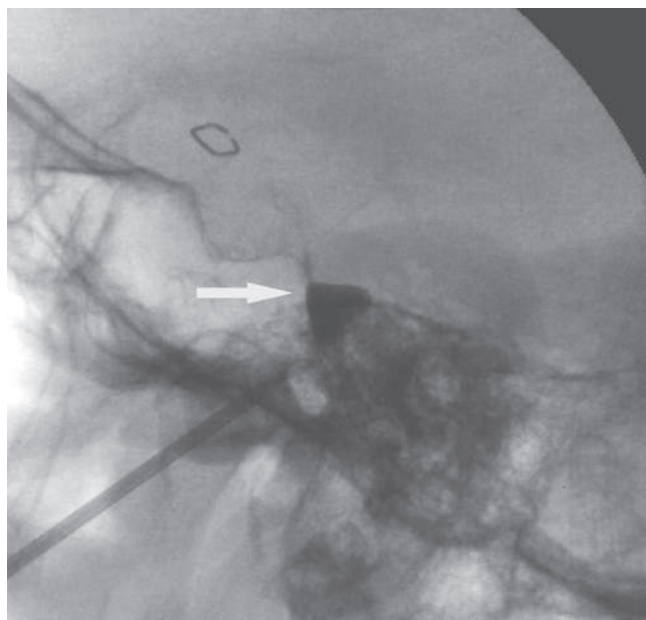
Lateral radiograph of the skull. Arrow points to a properly inflated balloon. The tip forms the pear shape and is located within the entrance to Meckel cave, the porous trigeminal.
